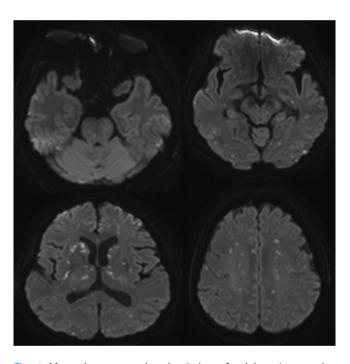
Magnetic resonance imaging 2 days after injury shows an increased number of tiny, multifocal, diffusion-restrictive lesions in the cerebrum, midbrain, pons, and cerebellum.
